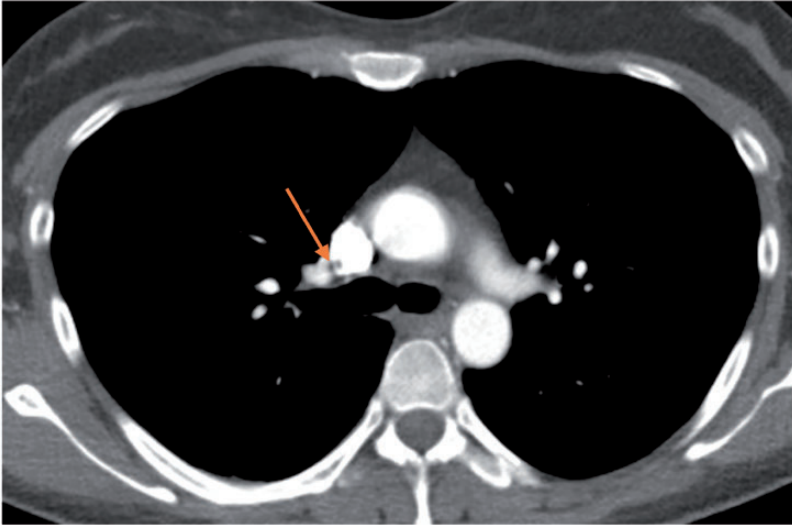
Enhanced computed tomography pulmonary angiography scan showed filling defects in the pulmonary artery (transverse plane).
